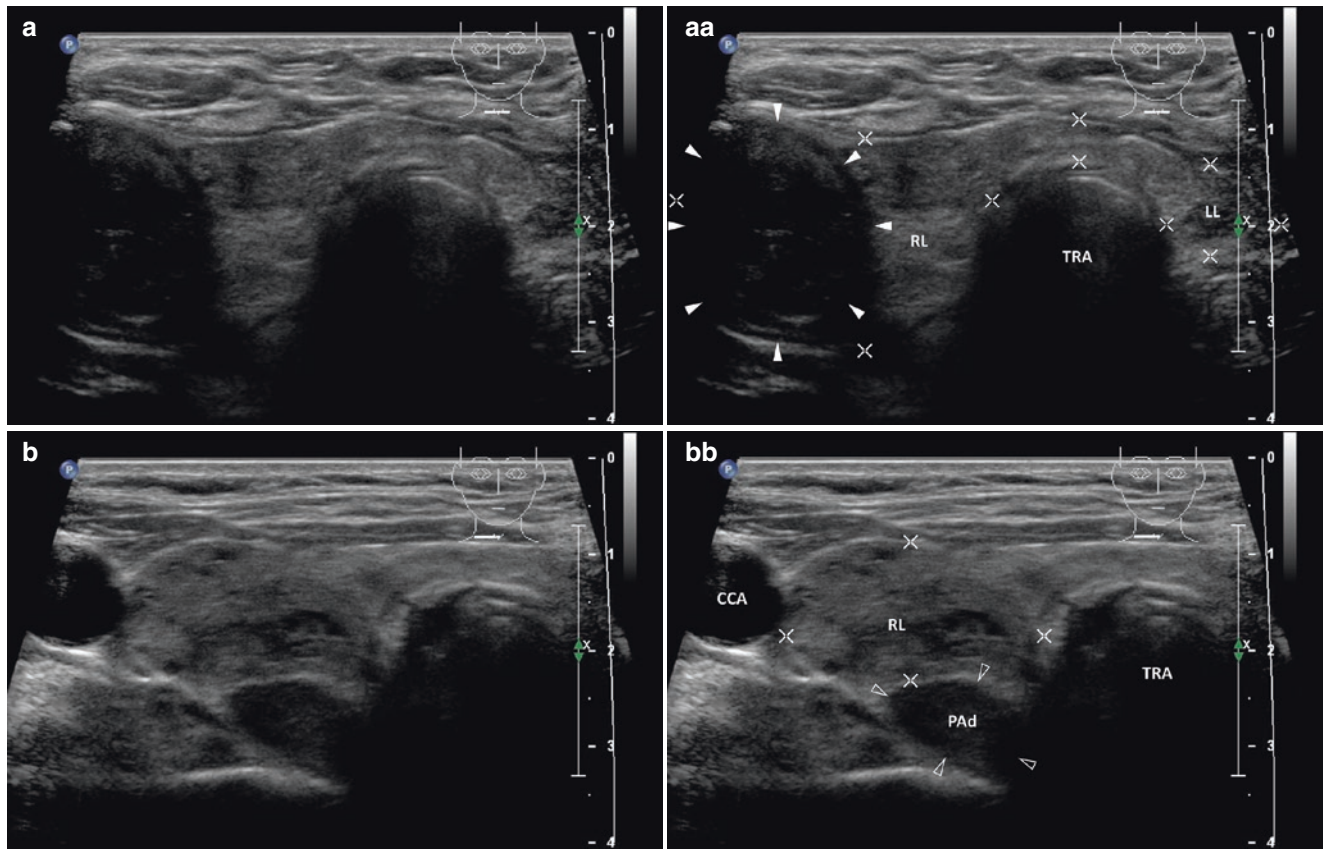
(aa) Case of large acute postoperative hematoma post total thyroidectomy and parathyroidectomy. A 69-year-old man, polymorbid patient with history of myocardial infarction, permanent atrial fibrillation with anticoagulant therapy, and end stage kidney disease on renal replacement therapy with secondary hyperthyroidism, presented with palpable resistance in the right jugulum. US appearance prior to surgery—multinodular goiter with large complex nodule (*arrowheads*), size $31 \times 26 \times 23$ mm and volume 10 mL in the RL: inhomogeneous structure; septated cystic cavities; Tvol 32 mL, asymmetry—RL 22 mL and LL 10 mL; transverse. (bb) US appearance prior to surgery—detail of superior parathyroid adenoma (PAd) behind the RL (*blank arrowheads*), size $23 \times 17 \times 9$ mm and volume 1.8 mL: elliptical shape; homogeneous structure; hypoechoic; transverse. (cc) US appearance prior to surgery—detail of complex nodule (*arrowheads*) and superior PAd (*blank arrowheads*): complex nodule in the central part of the RL and elliptical PAd behind the RL; longitudinal. (dd) Ten days after surgery there was a great resistance in the operating field. The long-term anticoagulation therapy was discontinued 1 week before surgery and low-molecular-weight heparin was initiated postoperatively. However, US revealed large acute post-thyroidectomy hematoma (*arrowheads*) in the thyroid lodge (confirmed by computed tomography). US overall
